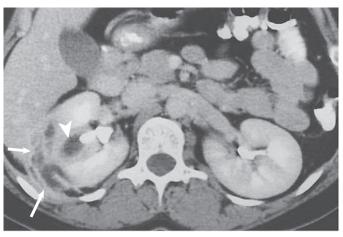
Renal abscess. Contrast-enhanced CT scan shows an abscess in the medulla of the kidney *(arrowhead)* with penetration and extension into the perinephric space *(arrows)*. (Courtesy L. Towner.)
